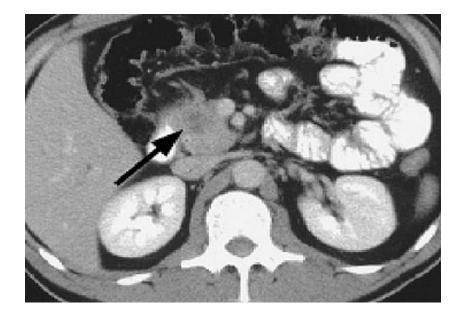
3 CT Scan-Pancreatic head carcinoma
